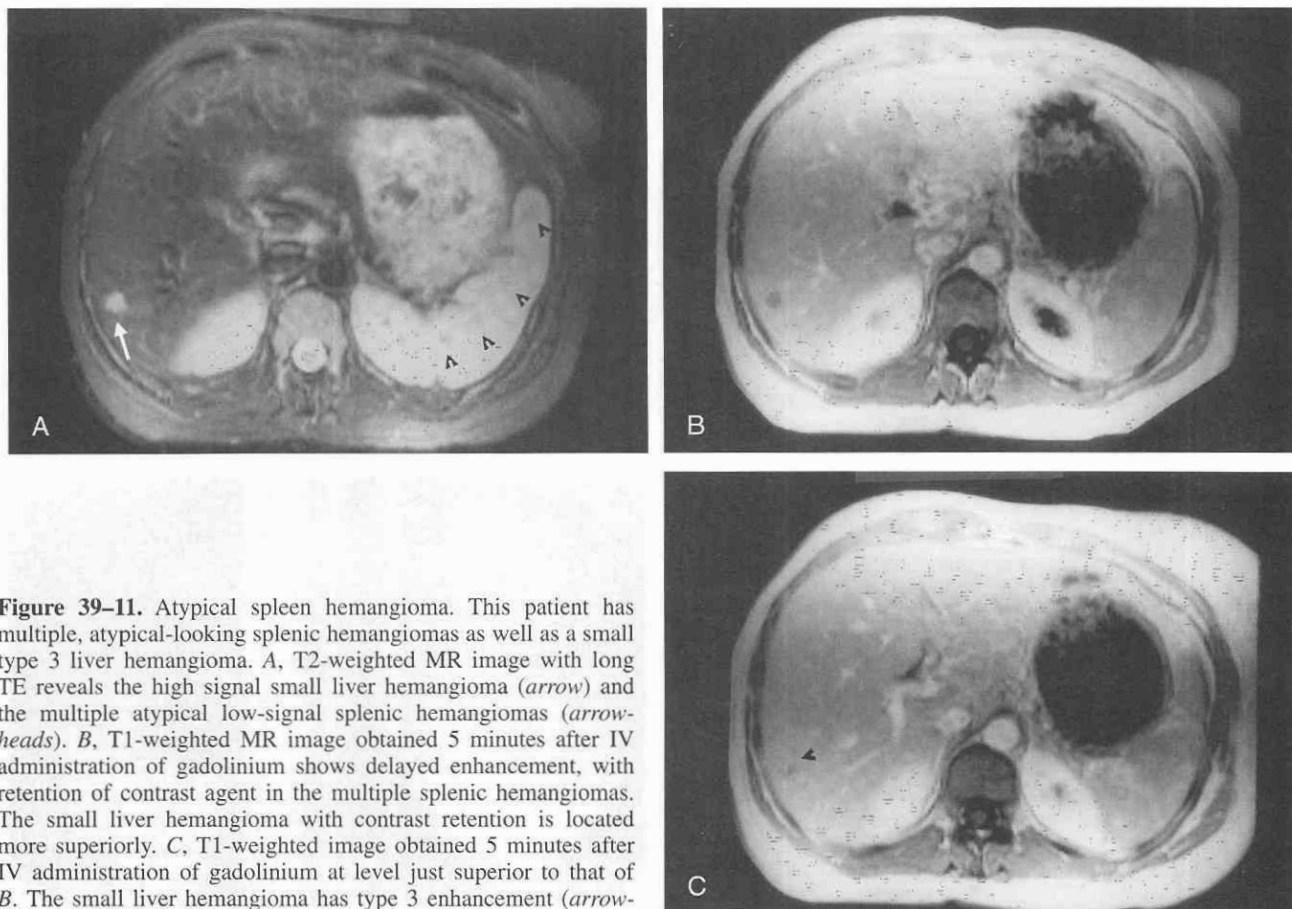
Atypical spleen hemangioma. This patient has multiple, atypical-looking splenic hemangiomas as well as a small type 3 liver hemangioma. *A*, T2-weighted MR image with long TE reveals the high signal small liver hemangioma (*arrow*) and the multiple atypical low-signal splenic hemangiomas (*arrowheads*). *B*, T1-weighted MR image obtained 5 minutes after IV administration of gadolinium shows delayed enhancement, with retention of contrast agent in the multiple splenic hemangiomas. The small liver hemangioma with contrast retention is located more superiorly. *C*, T1-weighted image obtained 5 minutes after IV administration of gadolinium at level just superior to that of *B*. The small liver hemangioma has type 3 enhancement (*arrowhead*) with incomplete enhancement. Additional splenic hemangiomas can be seen.
